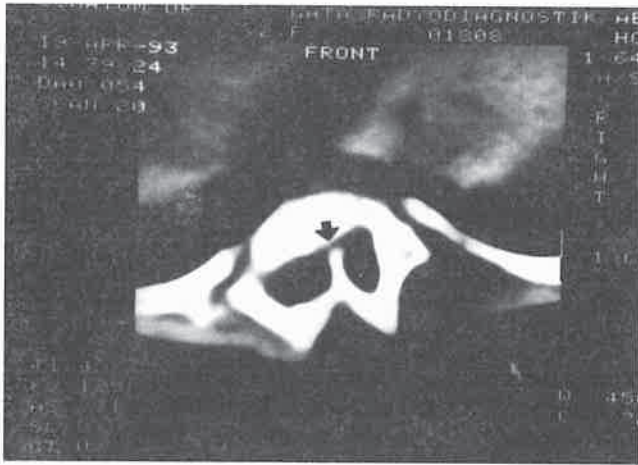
a and b: CT-scan showing median bony septum at thoracic 10 and lumbar 2 (arrows).
